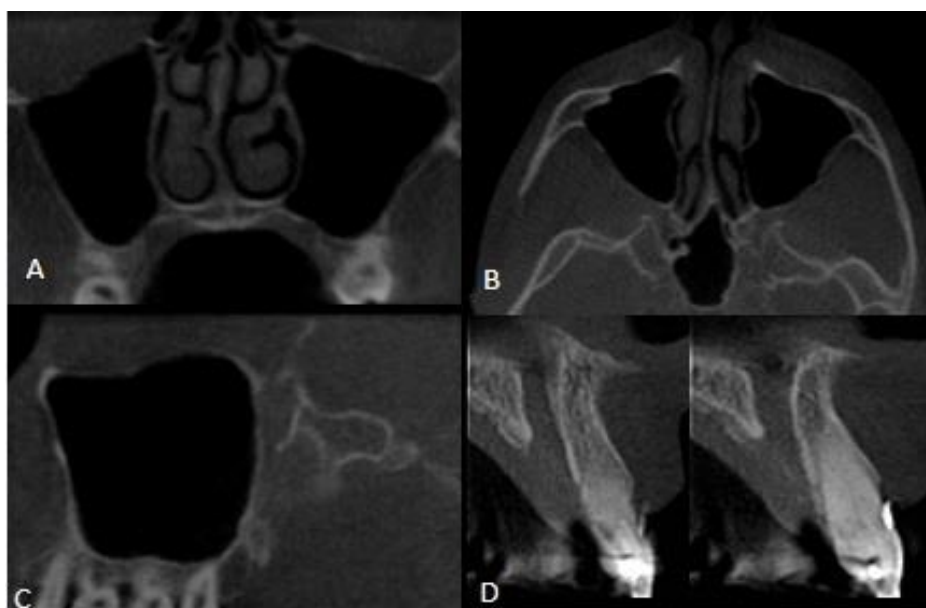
Periapical inflammation
